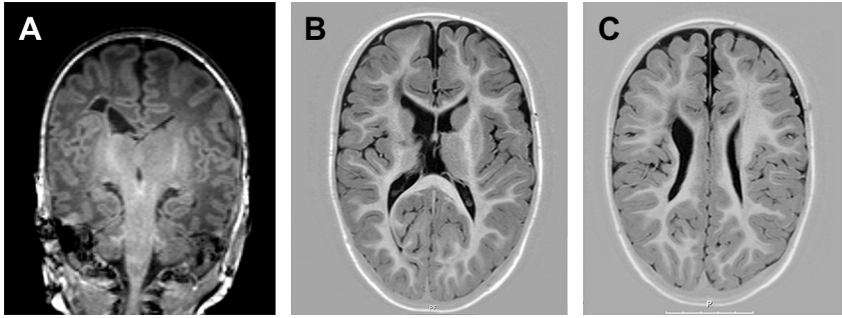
MRI, T1-weighted image at term-equivalent age and at 2 years of age in a preterm born infant (gestational age 26 weeks). A single cyst is seen adjacent to but not communicating with the lateral ventricle. A PVHI is noted on sequential cUS. Asymmetry in myelination is seen (A). At 2 years, an interruption of the posterior limb of the internal capsule is seen as well as an area of low signal intensity adjacent to the mildly dilated right ventricle (B, C). The child developed a mild unilateral spastic cerebral palsy.
